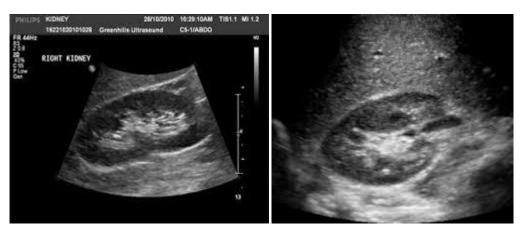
Longitudinal and transverse views of the normal right kidney. (<u>www.ultrasoundpaedia.com</u>)
